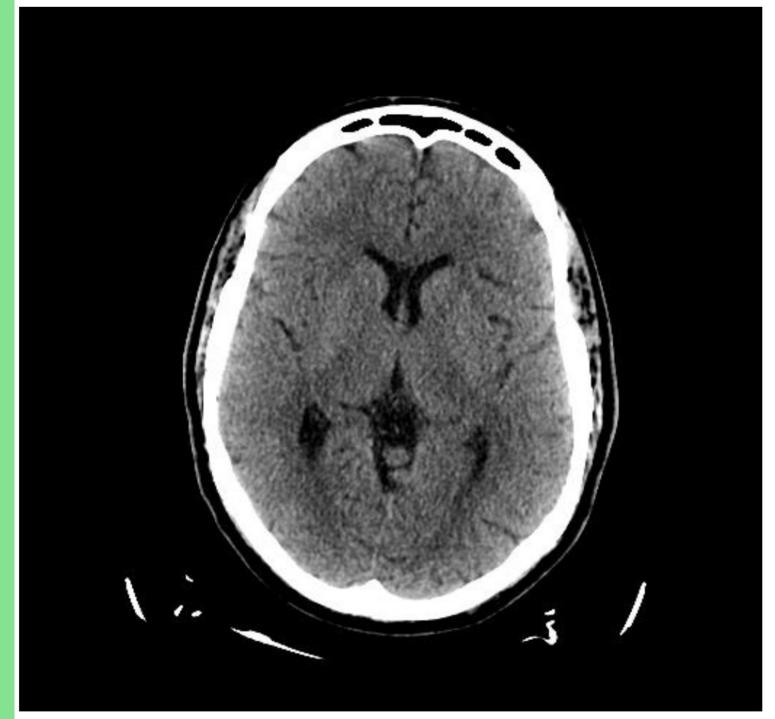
1 CT Head imaging on arrival
